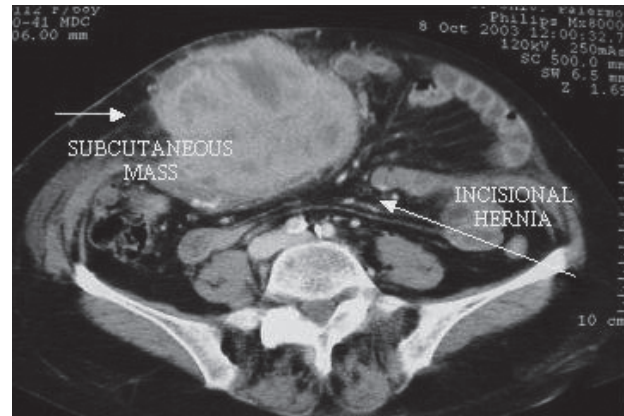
CT scan shows the presence of a periumbilical hernia. On the right side, close to the hernial sac, a solid-disomogenous mass with colliquative areas inside was demonstrated.
